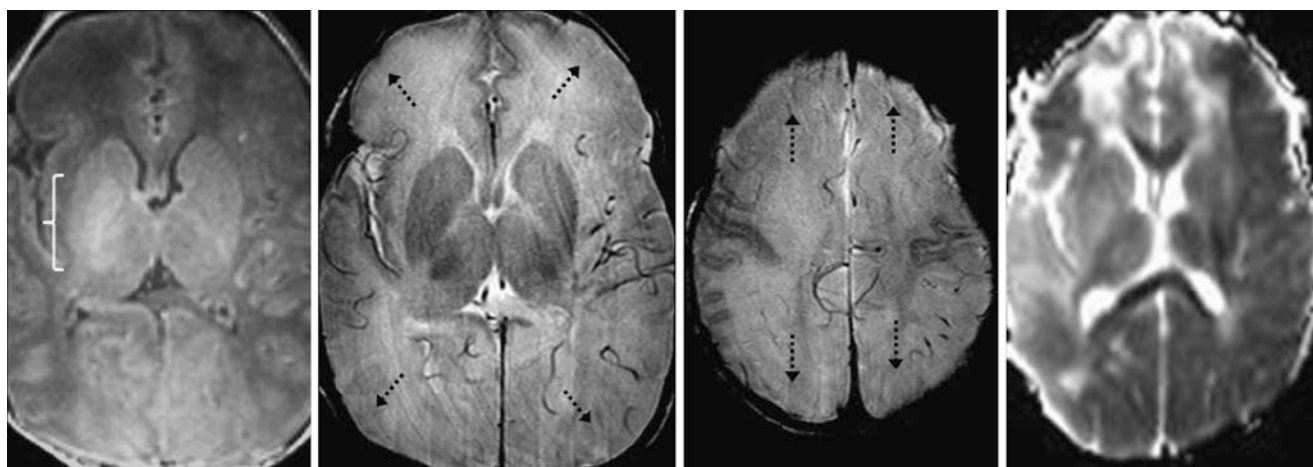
Comparison case of severe HII. A 4-day-old term neonate with hypotonia following a respiratory event had a 3T MRI. GE T1WI (left) showed loss of the normal T1-bright central structures on the left, such as the basal ganglia, VLT, and PLIC, while on the right (bracket), these were too hyperintense, “blotchy,” and could not be
